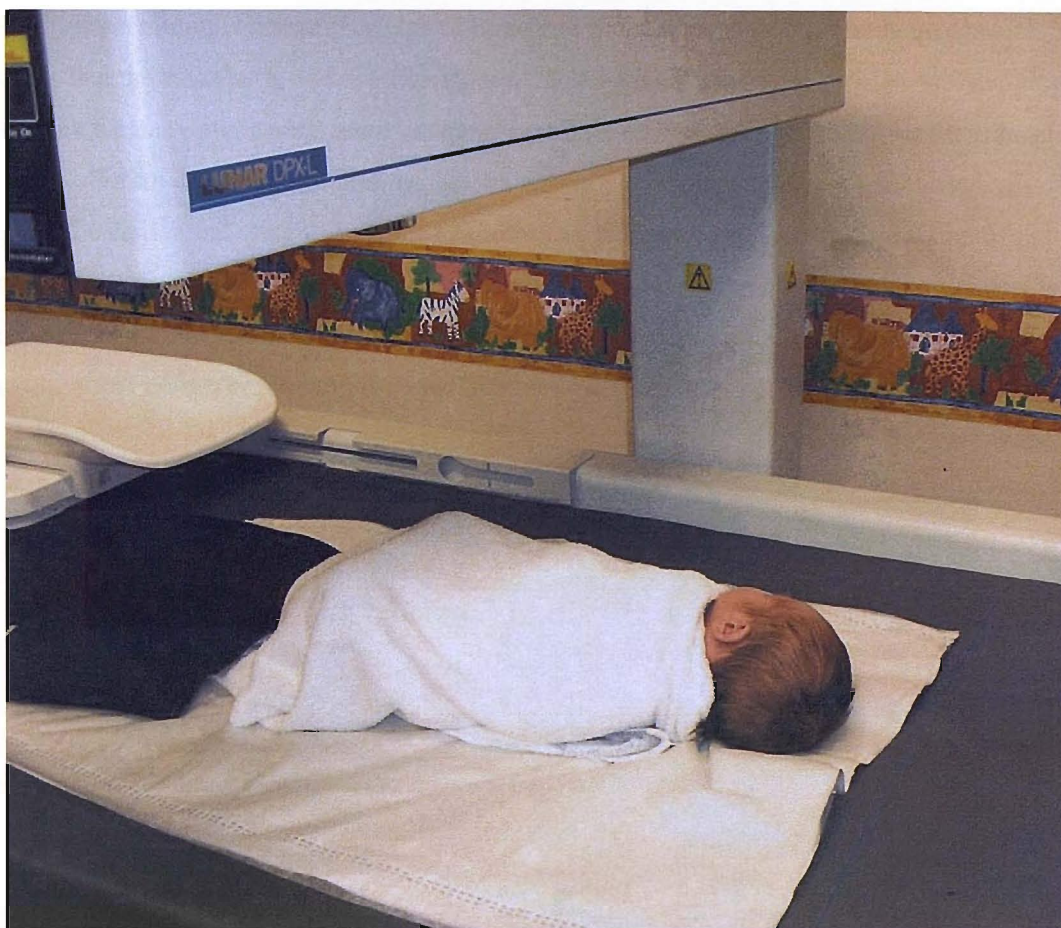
A sleeping infant undergoing a DXA examination. The sleeping infant is placed on the black radiopaque mattress. The gantry above the baby moves slowly down the length of the baby emitting x-rays as it proceeds. The x-radiation is detected by sensors beneath the table.
